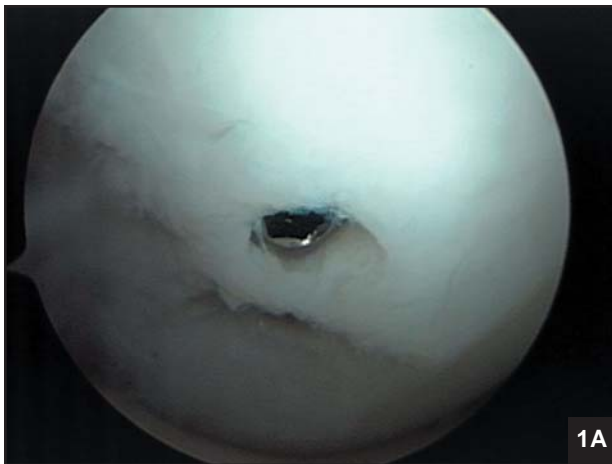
The goal for successful osteochondral healing is to promote bone-to-bone healing with restoration of a congruent joint surface using basic biologic and mechanical principles implemented in articular fracture care. Arthroscopic photograph of an anatomically reduced lesion of osteochondritis dissecans treated with a cannulated compression screw (A). Plain radiograph demonstrating the lesion and screw with the head of the screw at the subchondral bone (B).
